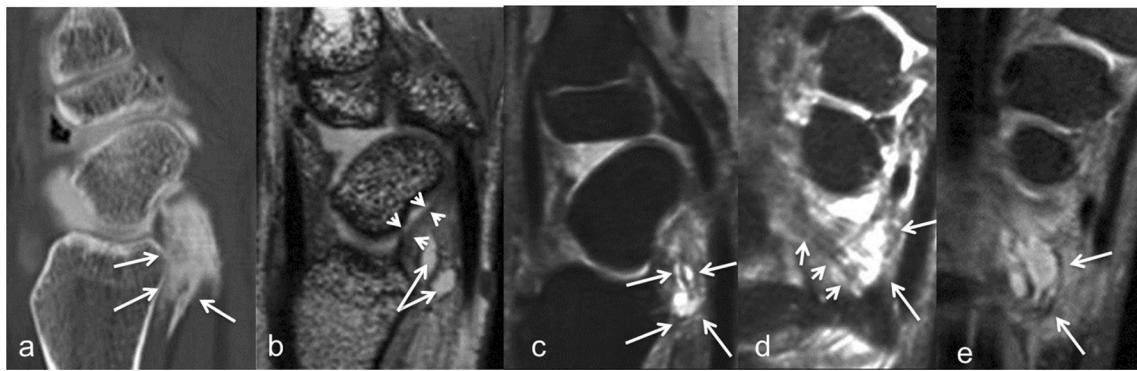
a–e Sprained proximal radioscaphocapitate ligament (RSC). Contrast extravasation is noticed in front of the distal radial epiphysis on a sagittal reconstructed CTA image (a, *arrows*) suggesting the presence of a proximal RSC lesion. On thin 0.5-mm-sagittal reconstructions from a 3D DESS (b) sequence and a 3D fat saturated
